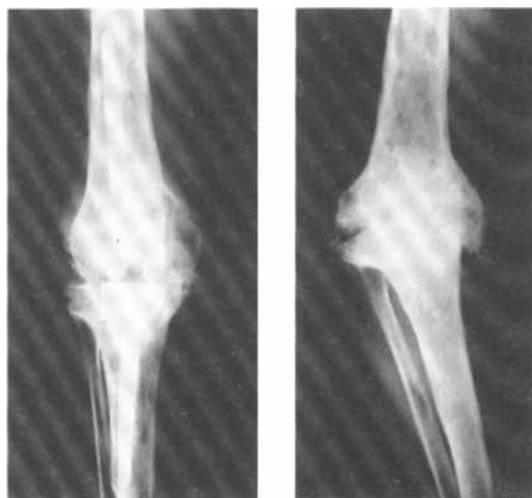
Radiographs of an infected Sheehan arthroplasty with the prosthesis in situ and following removal and arthrodesis. The result is a pain free stable but fibrous ankylosis.
